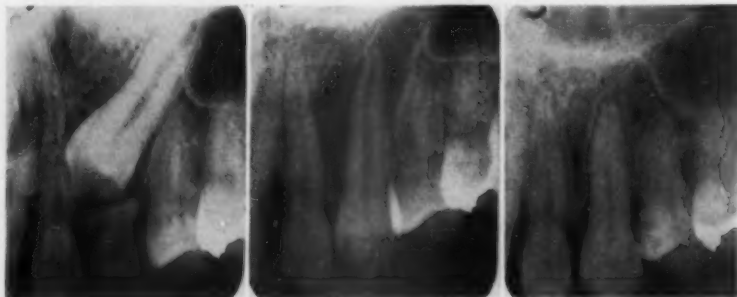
Original radiograph, one month postoperatively, and ten months postoperatively.
